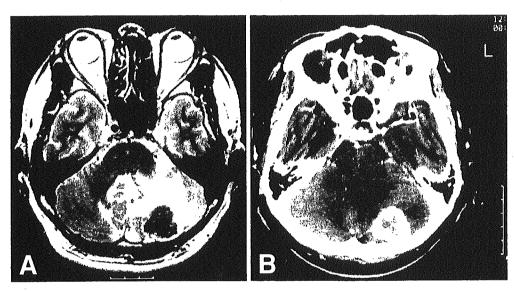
Imaging scans in a 53-year-old man who developed cerebellar metastasis 5 years after resection of colorectal cancer. A T2-weighted MRI scan (A) showed marked perifocal edema, although the tumor itself was only 2.2 cm in diameter. Nine days later, a computed tomography (CT) scan (B) revealed that the tumor had grown to
